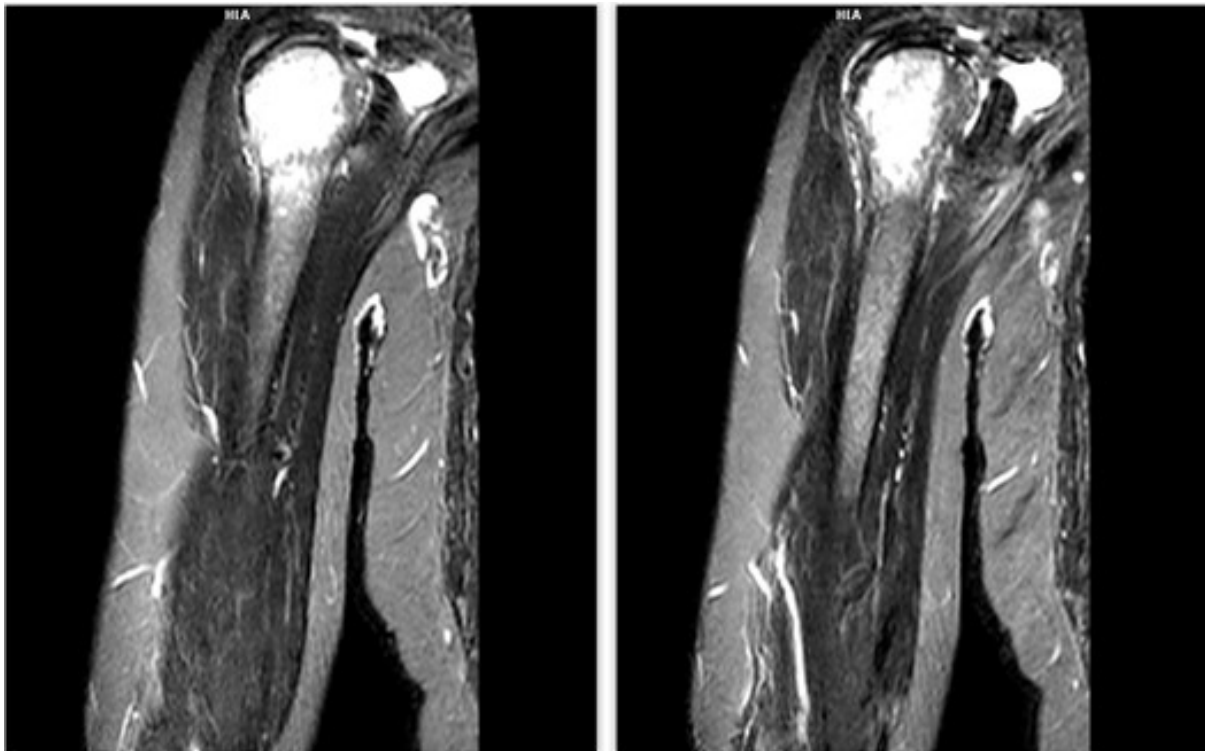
Coronal MRI image showing a lytic, expansile lesion in the proximal right humerus with cortical destruction, consistent with bone metastasis.
